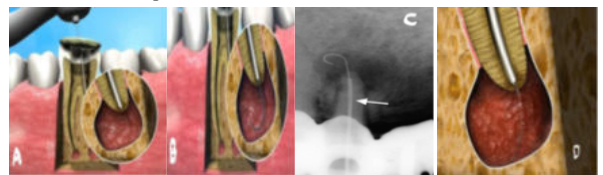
(A) Apexum NiTi Ablator inserted in periapical region. (B) The Apexum NiTi Ablator pushed in and extruded from its sheath. (C) The Apexum NiTi Ablator in a periapical lesion fully extruded from its sheath (arrow). (D) The Apexum PGA Ablator with bioabsorbable filament in periapical region¹⁰.
